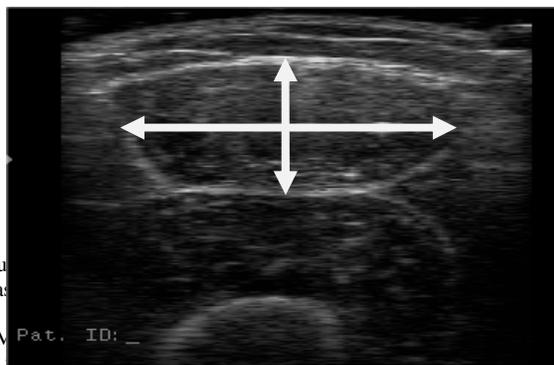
Ultrasound image of the rectus femoris (RF) muscle showing measurement lines for width and depth.
